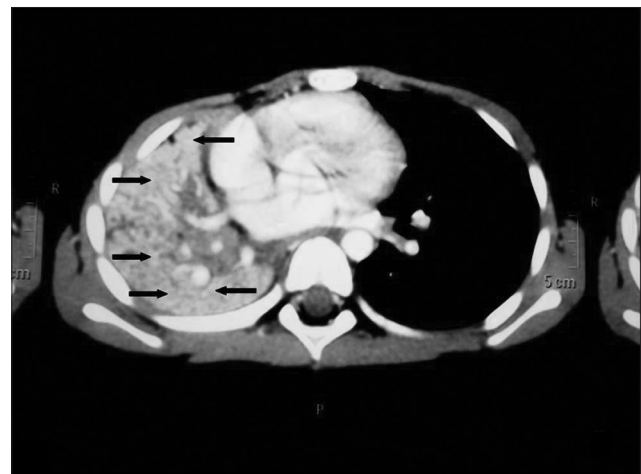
CT scan displays multiple obstructed lobar and segmental bronchi (black arrows) in the atelectatic right lung. No foreign body is shown whereas the left lung shows compensatory hyperaeration. Note the mediastinal shift toward the atelectatic side
